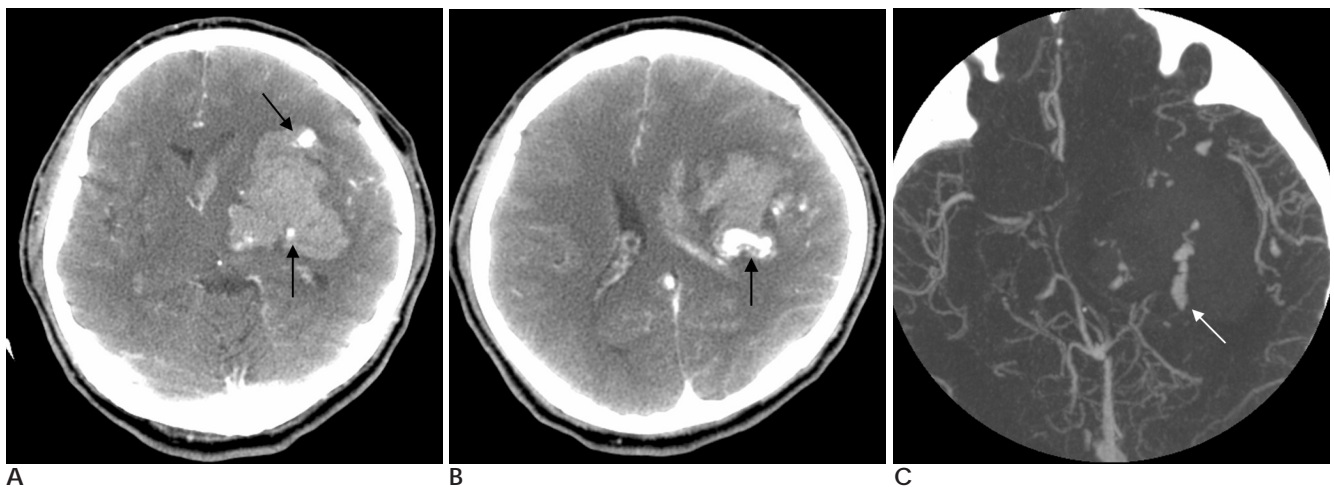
Brain CT and CT angiography with Type B contrast extravasation in a 46-year-old man with an acute spontaneous ICH.
